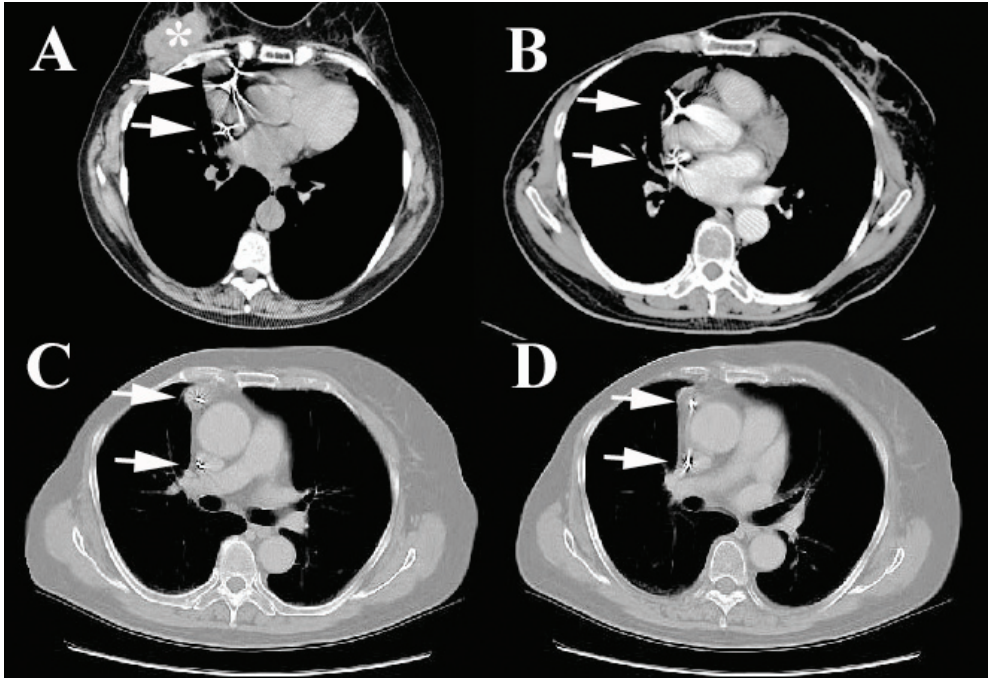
Computed tomography. (A) Before the replacement of the pacemaker, the scan showed right breast cancer (asterisk) and an atrial lead (arrows). (B) Nine months after the replacement, the new atrial lead (arrows) was screwed in almost the same position as the previous one, and had perforated the right atrial appendage. (C, D) Four years later, consecutive scans clearly showed the progression of the perforated atrial lead (arrows). (From Sadamatsu K, et al. (2009). Progressive atrial lead perforation developed 5 years after pacemaker replacement. *J Cardiol*, 53,150-153)
